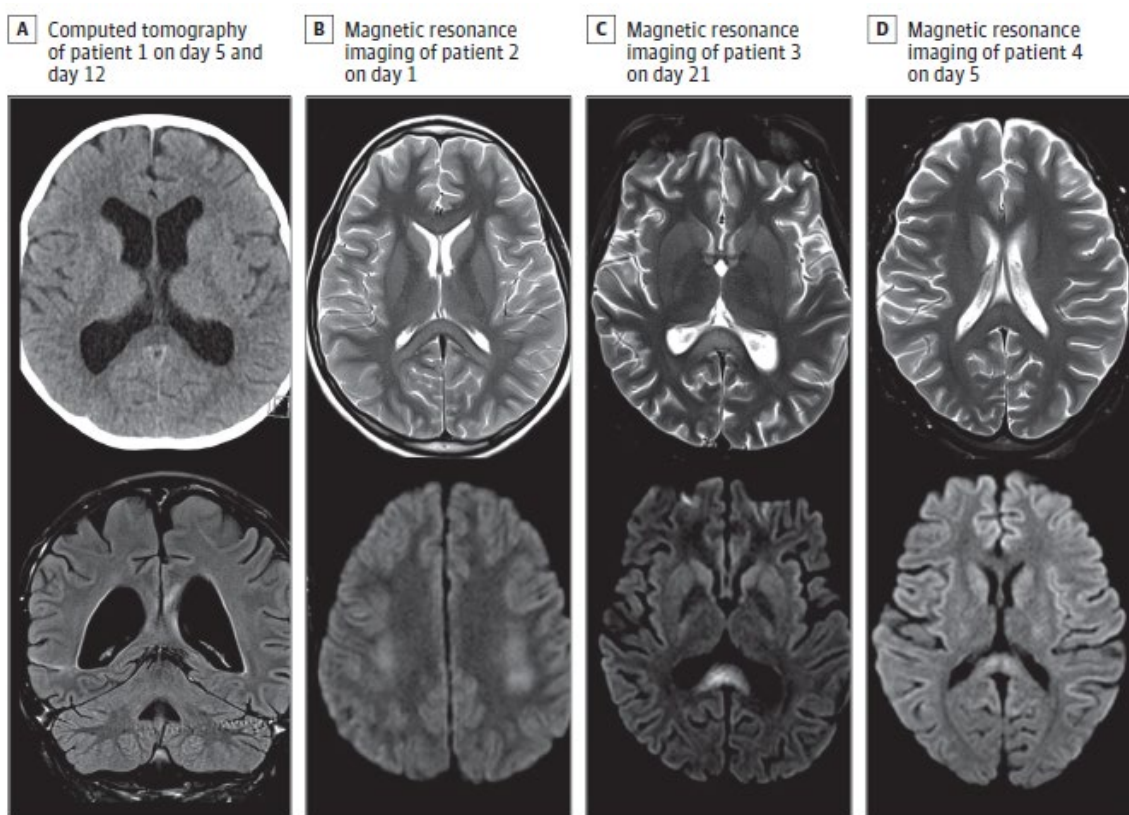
Neuroimaging Findings in Association with Coronavirus Disease 2019 in Children. A, CT image of patient 1 on day 5 (top), during intensive care admission, showing hypodensity of the splenium of the corpus callosum (SCC). Coronal fluid-attenuated inversion recovery performed on day 12 (bottom) shows resolution of the changes previously seen on computed tomography, with persistent signal changes in the genu and SCC without restricted diffusion (not shown). B, Axial T2 MRI of patient 2 on day 1, showing signal changes of the genu and SCC (top) and bilateral centrum semiovale with restricted diffusion (bottom). Repeated imaging on day 6 (not shown) demonstrated resolution of the restricted diffusion, with minimal signal changes remaining on T2-weighted imaging. C, Axial T2 MRI of patient 3 on day 21, showing hyperintensities (top) with restricted diffusion (bottom) in the SCC and bilateral centrum semiovale (not shown). D, Axial T2 MRI of patient 4 on day 5 (top), showing signal change in the SCC with mild restricted diffusion (bottom).
